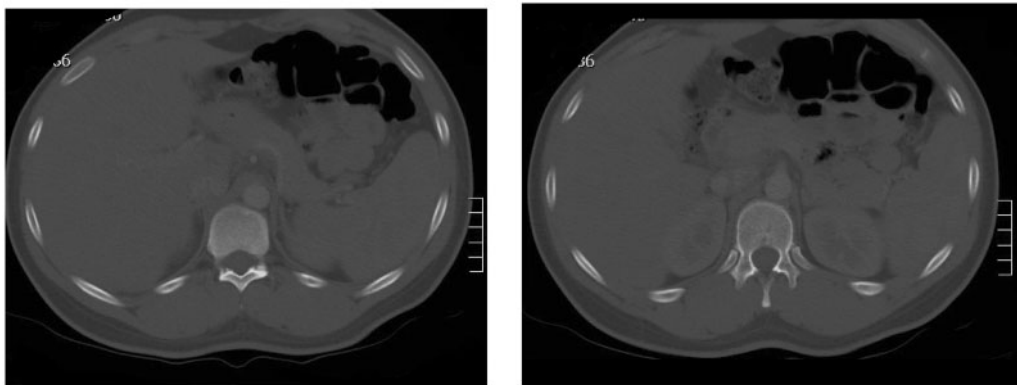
Plain CT scan showing oedematous pancreatic tissue with no obvious indication of a foreign body.
